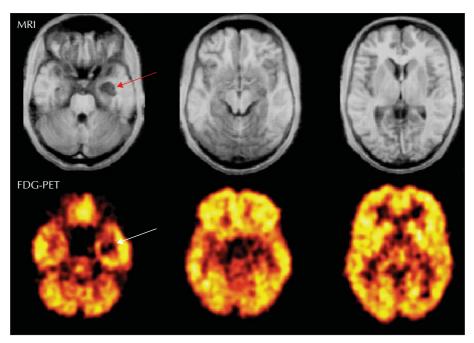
[18F]FDG-PET in a patient with an epileptogenic left amygdala cavernoma. Apart from the signal void observed at the location of the vascular malformation, no metabolic abnormality is detected in the surrounding epileptogenic cortex.
